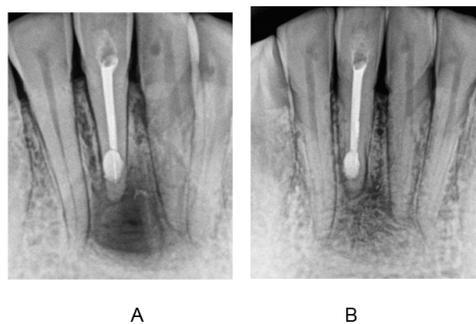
Evident reduction in the size of radiolucency radiographically in three months (A) and marked reduction seen radiographically 6 months (B) afterwards, a radiopaque area can be seen where the lesion used to be, suggesting the formation of new healthy bone.
